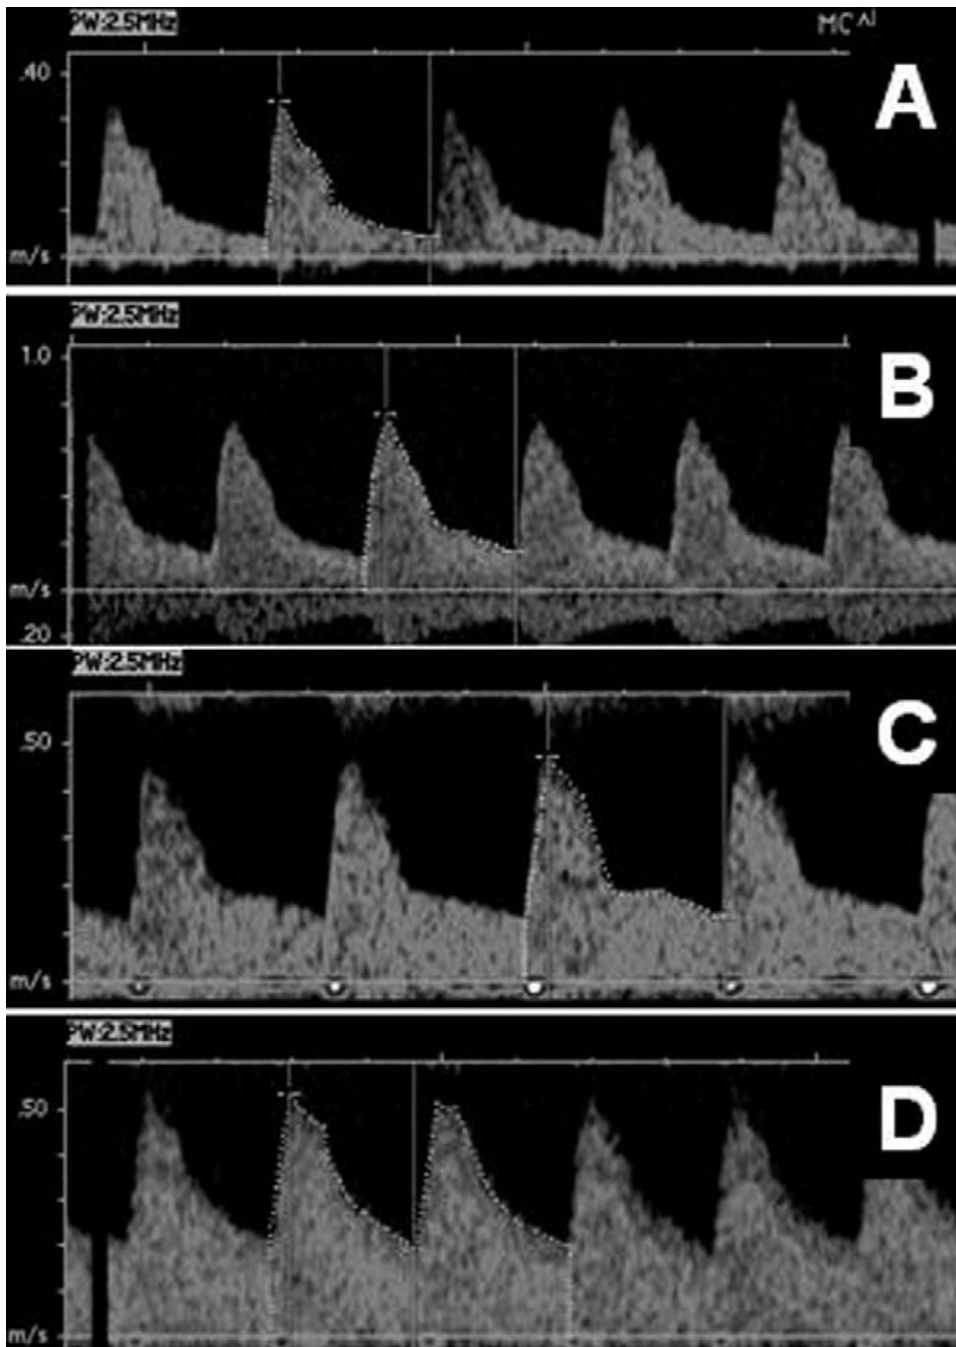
The normal middle cerebral artery flow pattern has relatively little diastolic flow (A). With elevation of placental blood flow resistance the changes in the middle cerebral artery waveform may be subtle, although the cerebroplacental ratio may become abnormal as in fetus B. With progressive placental dysfunction there may be an increase in the diastolic velocity, resulting in a decrease in the Doppler index (Brain sparing, C). With marked brain sparing, the systolic down slope of the waveform becomes smoother so that the waveform almost resembles that of the umbilical artery (D). The associated rise in the mean velocity results in a marked decline in the Doppler index. (Reprinted with permission.36)
